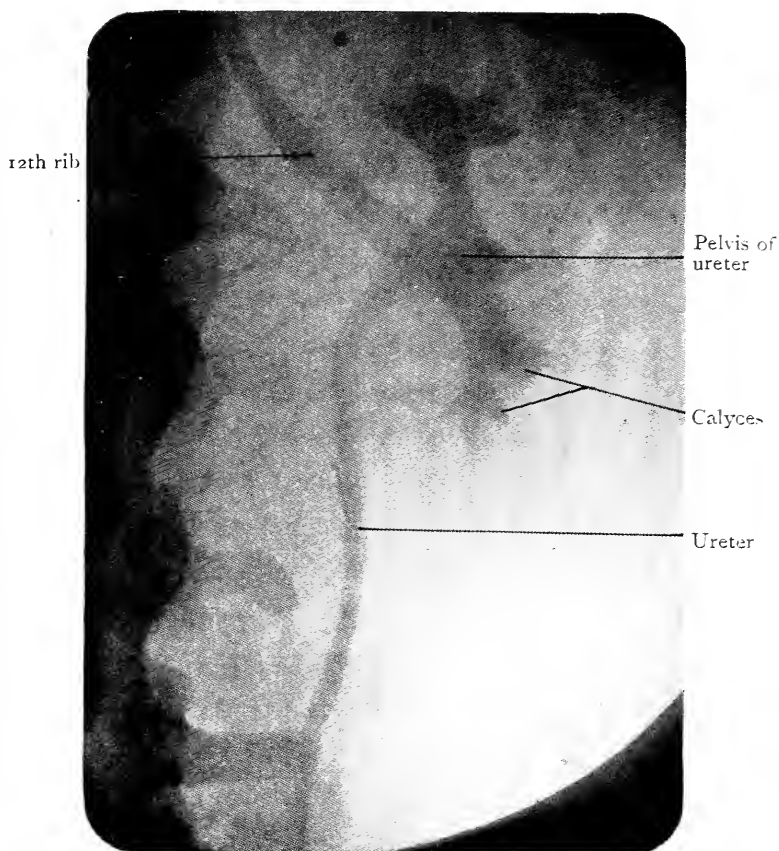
Radiograph of the Abdominal Part of the Left Ureter injected with collargol. (Frank Kidd, F.R.C.S.)
